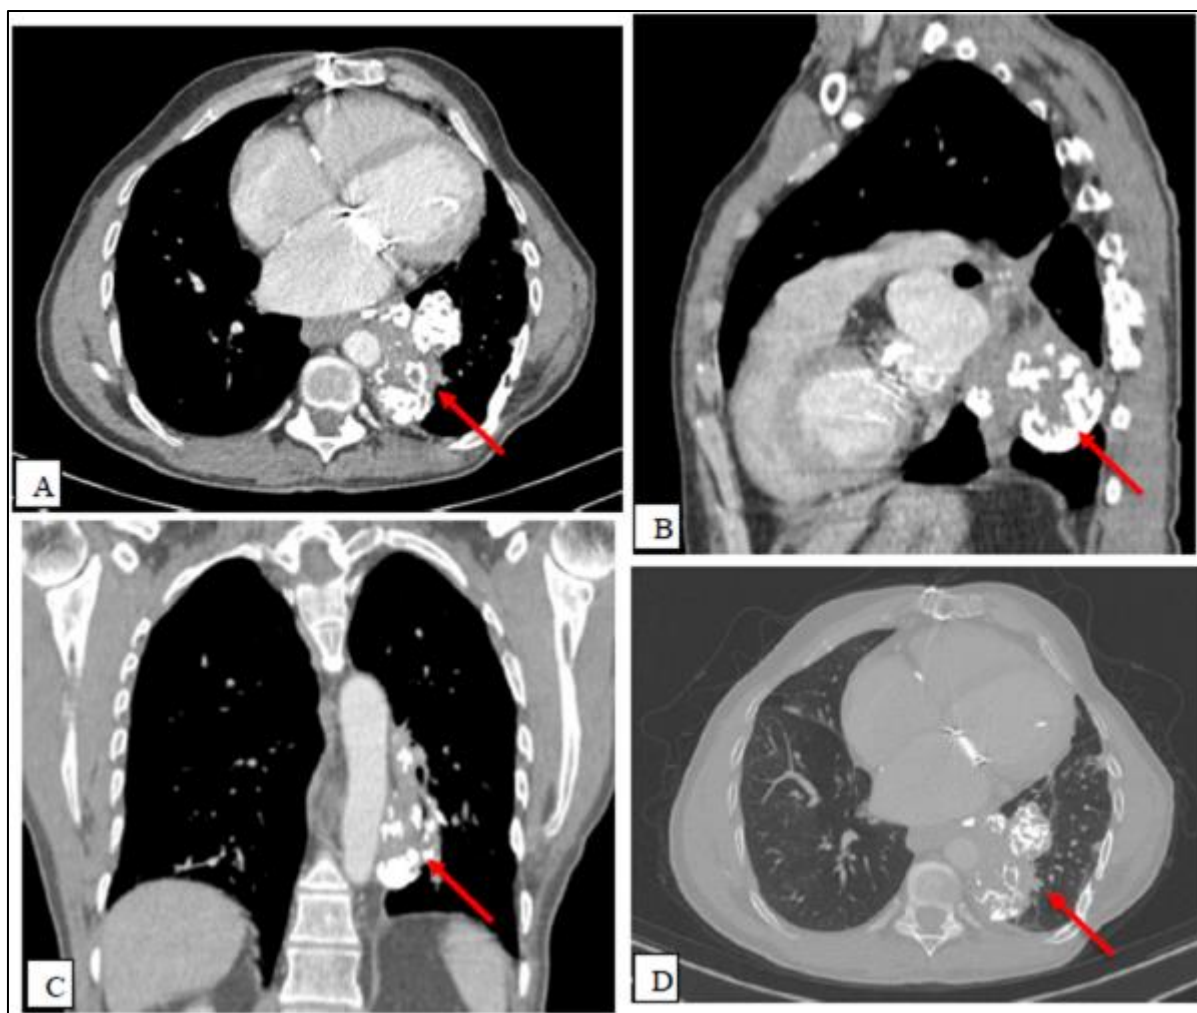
Follow-up contrast-enhanced thoracic CT (same planes and window settings as Figure 2). Axial (A), sagittal (B), and coronal (C) mediastinal window images, along with an axial lung window image (D), demonstrate interval partial regression of the left lower lobe mediastino-pulmonary mass (red arrow). The lesion has decreased in size, now measuring approximately 80 × 58 mm in axial dimensions, and shows a marked reduction of its soft tissue component with predominance of internal calcifications, consistent with treatment response.
